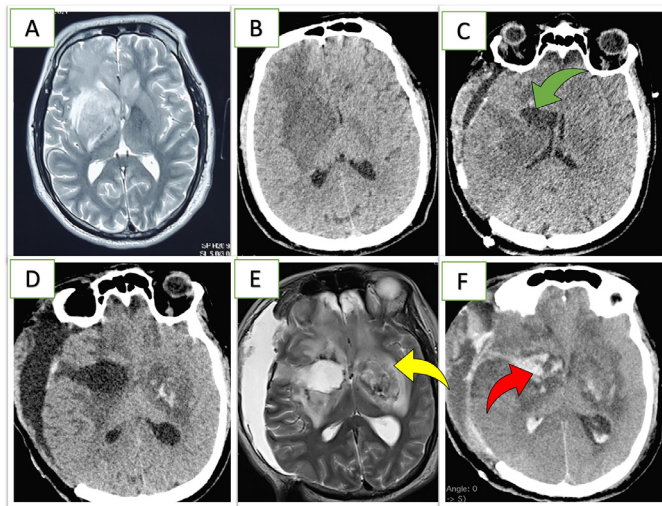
A) Day one, MRI (T2W) showing signal intensity changes in right basal ganglia, insula with extension to right frontal white matter, B) CT brain (plain) showing similar findings (as A) with mass effect, C) Postoperative day one CT brain (plain) showing excision cavity (green arrow), D) & E) Postoperative day five CT and MRI (Plain) showing mucus involvement of left basal ganglia with early bleed (yellow arrow) F) Postoperative day eight, CT scan showing extensive hemorrhage involving left basal ganglia, operative site, and lateral ventricles.
